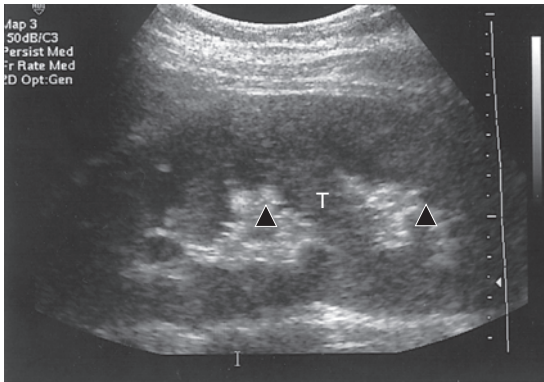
Duplex collecting system. A sagittal sonogram shows kidneys with two echogenic renal sinuses (▲) separated by cleft of tissue. (T)
